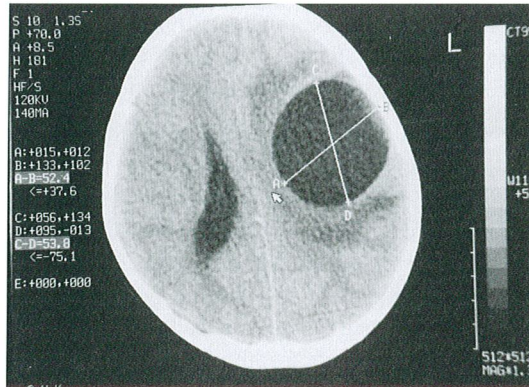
Plain CT scan showing a 6x8 cm cystic lesion with surrounding edema (arrows) in the left parietal lobe. A midline shift was also detected.
